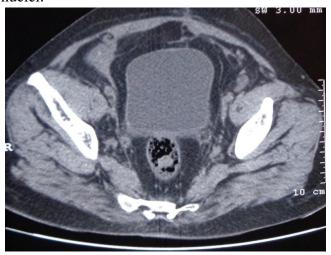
Computed tomography of pelvis showing post operative status (TAH + BSO) with no findings suggestive of disease recurrence.
